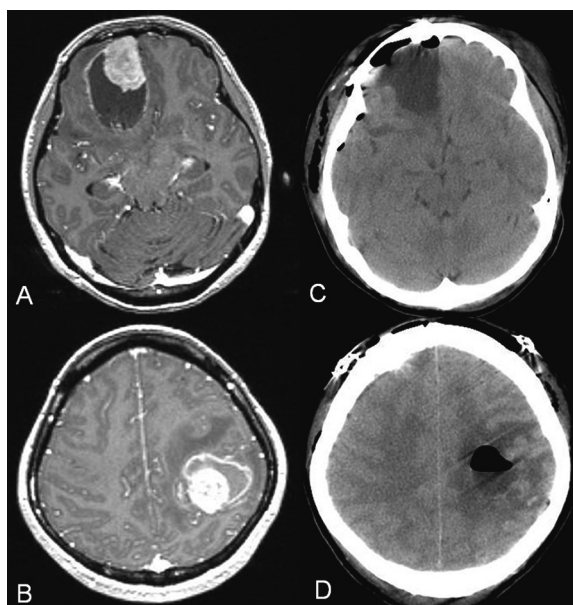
Magnetic resonance images show right frontal and left parietal tumor as strongly enhanced on T1-weighted image with gadolinium with peripheral edema (A, B). Postoperative computed tomography images show removal of the two tumors (C, D). Reprinted with permission from Simultaneous surgical resections of two distant metastatic malignant melanoma lesions—case report. Tanei T, Nakahara N, Takebayashi S, Hirano M, Wakabayashi T. Nagoya J Med Sci. 74 : 173-179, 2012.
